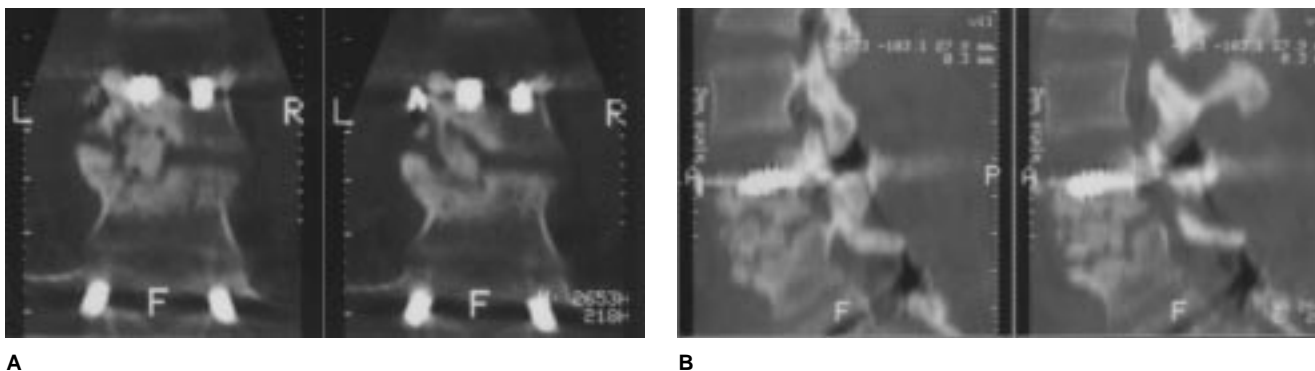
Anteroposterior (A) and lateral (B) computed tomographic reconstructions demonstrate pseudarthrosis of an anterior interbody bone graft.
